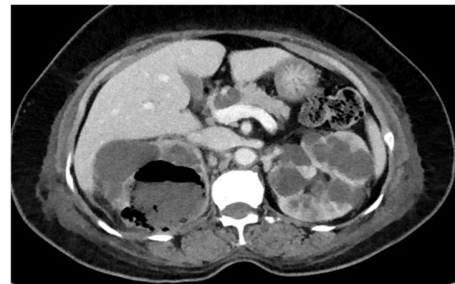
CT KUB showing polycystic kidneys with emphysematous infection
